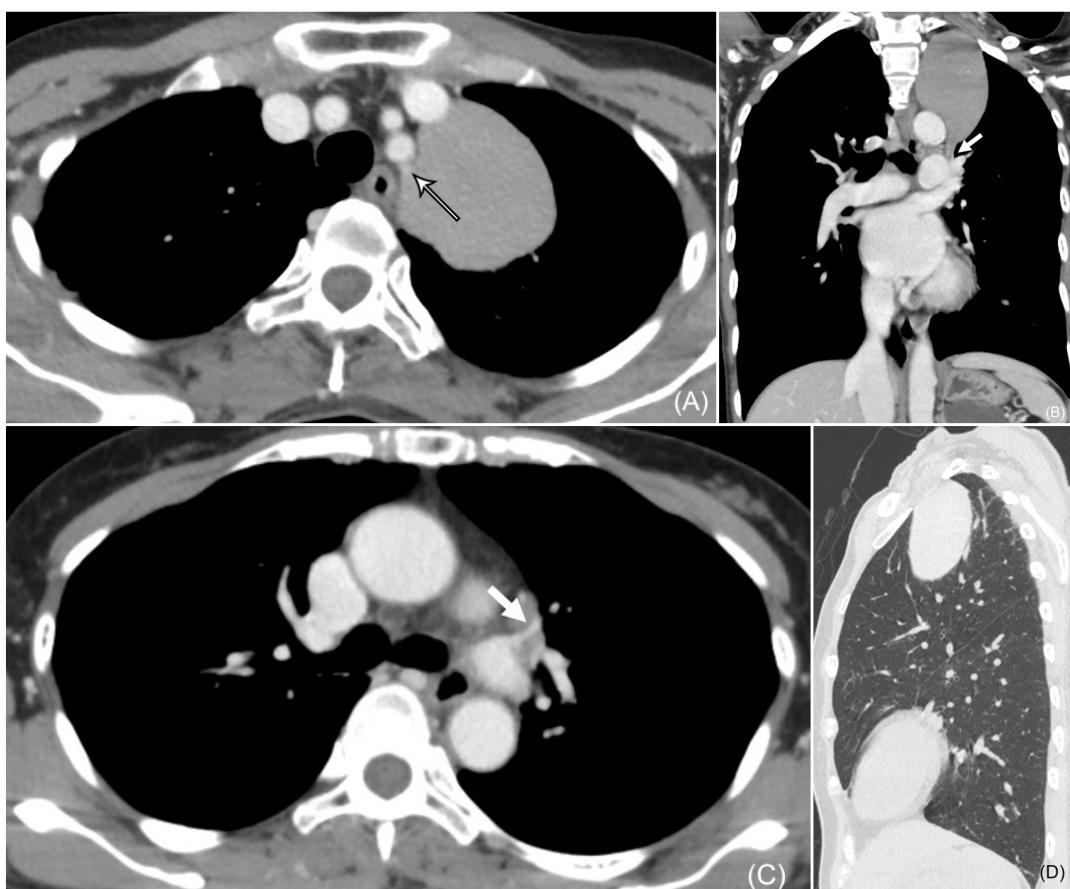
Axial (A) and coronal (B) contrast-enhanced CT images demonstrate a large, non-enhancing extrapulmonary mediastinal mass containing punctate calcifications and partially abutting the proximal left subclavian artery without invasion. An additional axial image (C) shows arterial supply from the left main pulmonary artery. Lung-window sagittal imaging (D) depicts bronchial displacement without bronchial communication, confirming the extrapulmonary origin.
